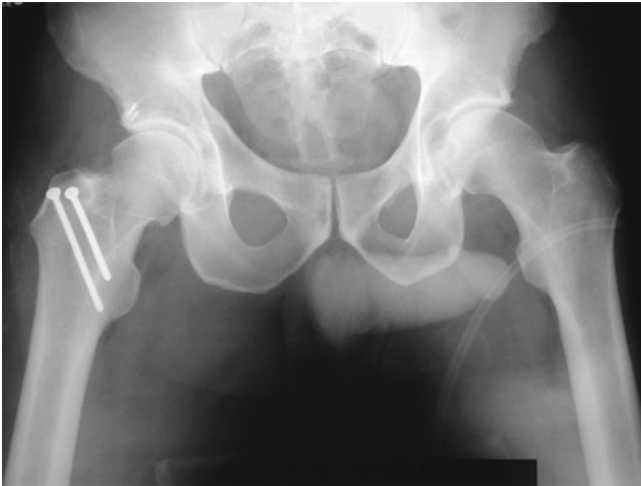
Postoperative radiograph of same patient in Fig. 6.1 after labral repair and osteochondroplasty
